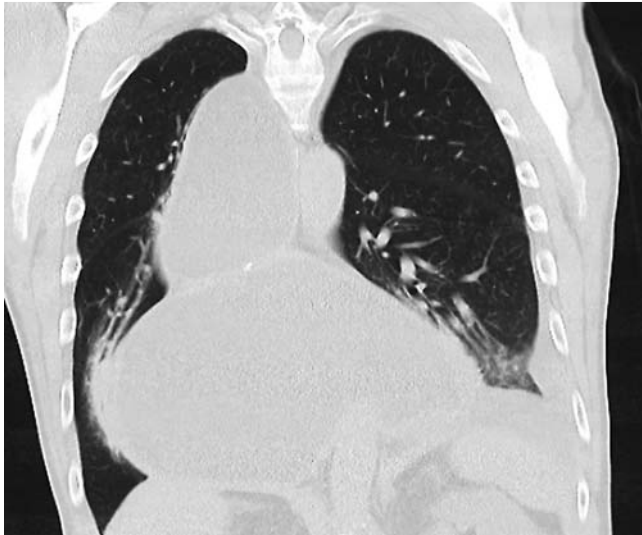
Computed tomography (CT) scan showing the dilated, fluid-filled intrathoracic stomach and a left-sided pleural effusion.
